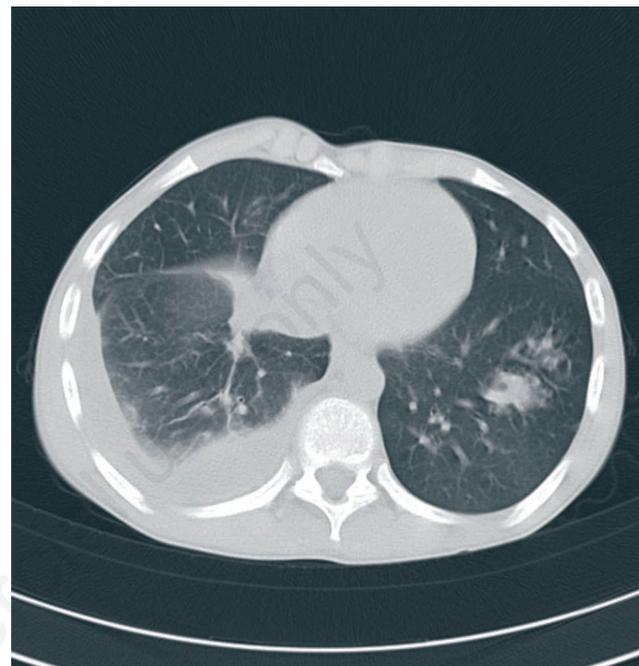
Computed tomography of chest showing right sided pleural effusion.
